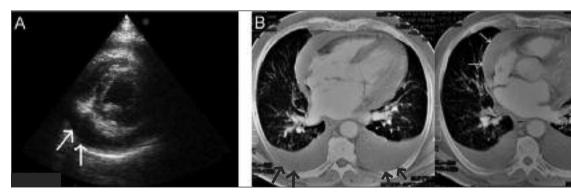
In addition to pericardial effusion (white arrows) on echocardiography (A) and CT (B), pleural effusion (black arrows) and vascular enlargement, due to increased pulmonary capillary pressure are seen on CT.
